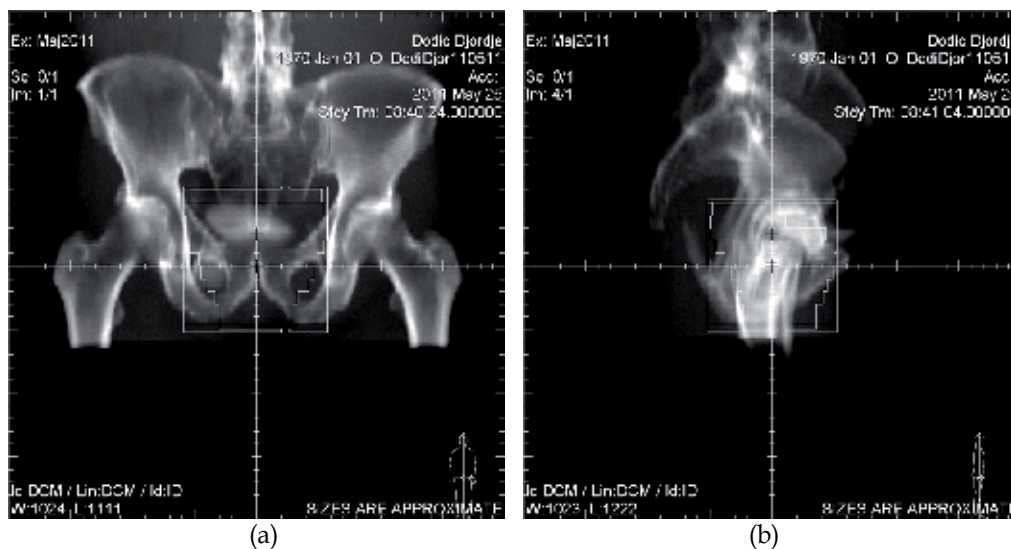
Digitally reconstructed radiographs (DRR) for AP (a) and right lateral (b) field (With thanks to the Institute for oncology and radiology of Serbia, Belgrade)
